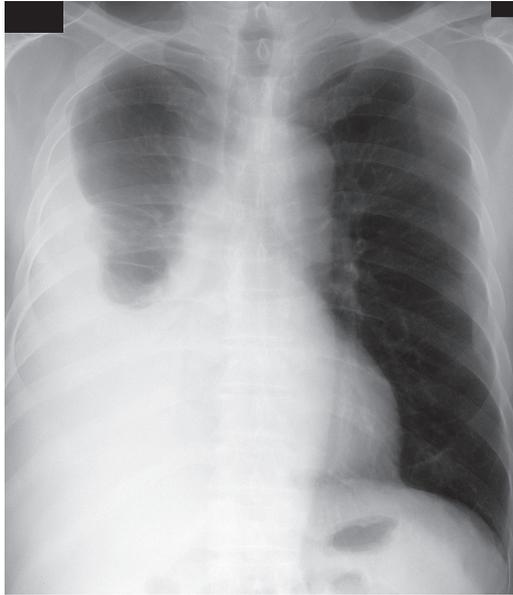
Chest radiograph on the admission, right-sided massive pleural effusion is noticed.
